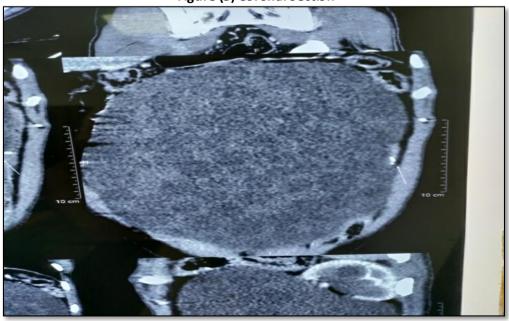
(4) & (5): A Computed Tomography Scan (CT) was performed for the patient that revealed approximately 31 x 23.6 x 7.8 cm (AP x TR x CC) sized intraperitoneal thin walled cystic lesion with calcification within it (arrow in figure 5) involving abdominal cavity more on left side extending from epigastric region to left iliac fossa region and reaching upto the anterior and left lateral abdominal wall.
